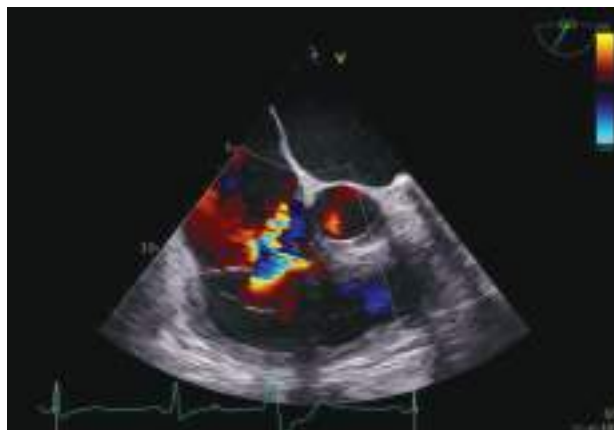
Ultrasound showing severe tricuspid regurgitation
